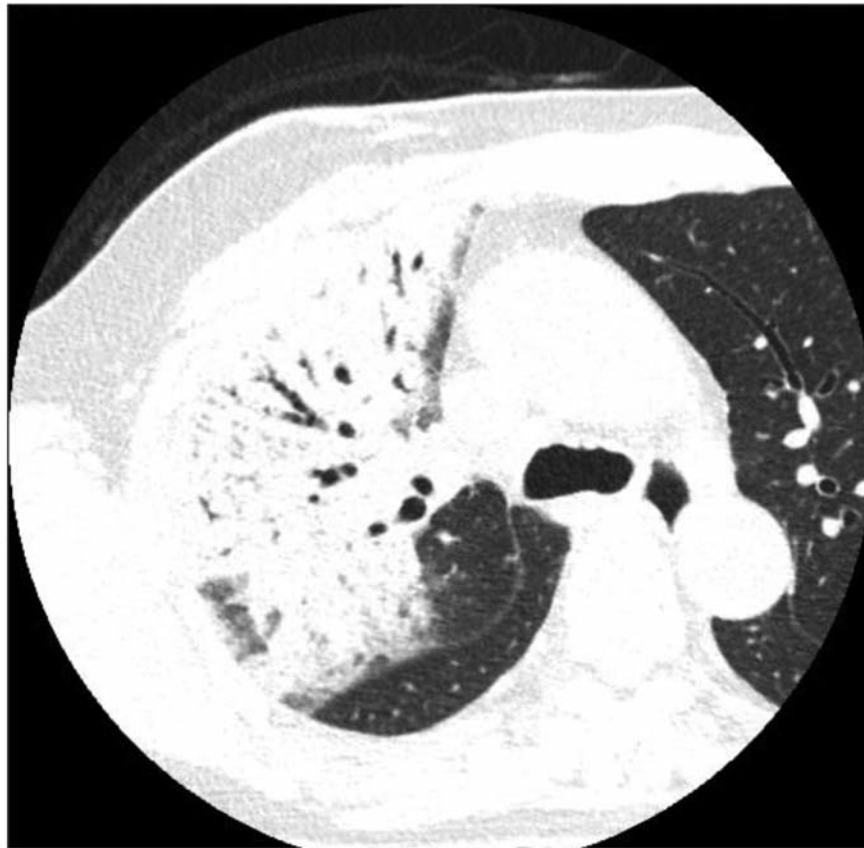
A 61-year-old woman with cancer in her right breast developed symptomatic radiation pneumonitis five months after accelerated partial breast irradiation. The chest computed tomography image demonstrated pulmonary infiltration and air bronchogram.
